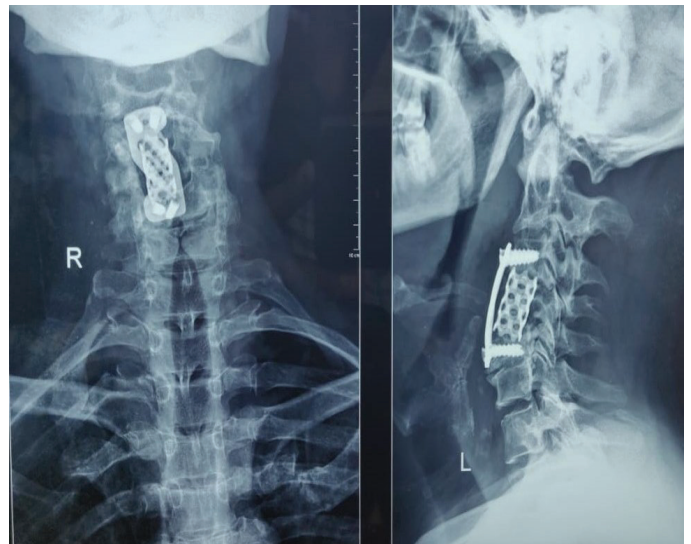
Post-operative X-ray with anterior plate and Harm's cage at C4
